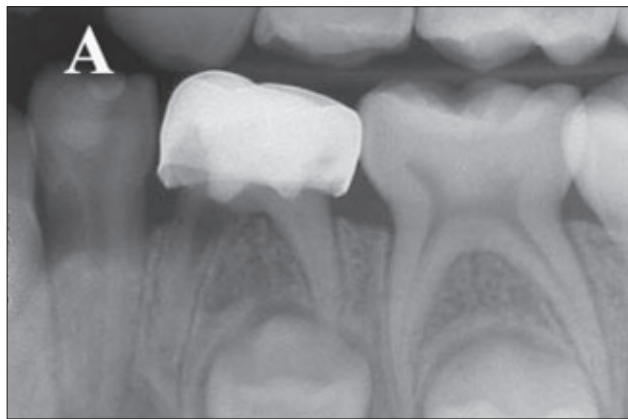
Left bite-wing radiograph of an 8-year, 2-month-old girl. Primary mandibular first molar with internal resorption in the mesial root 38 months after performance of pulpotomy with MTA.
